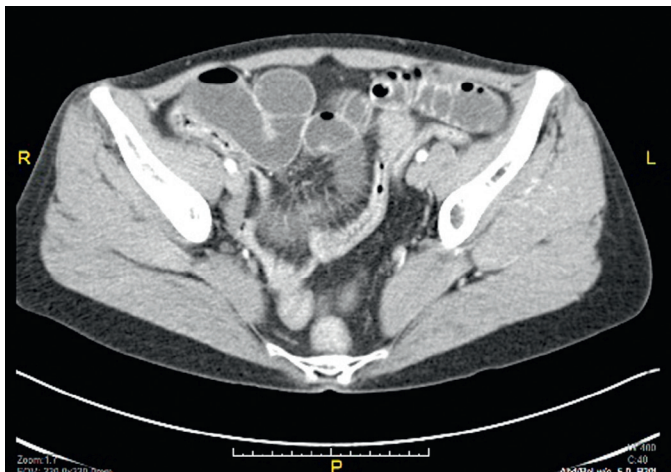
■ Small bowel obstruction. Abdominal computed tomography scan demonstrates a clear transition point between the dilated and decompressed small bowel.
